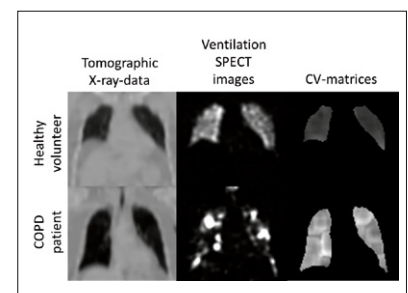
Top row shows a healthy volunteer and bottom row a patient with severe COPD. Notice the patchy gas distribution in the SPECT image and resulting high CV values in the CV-matrix for the patient compared to the healthy volunteer.
